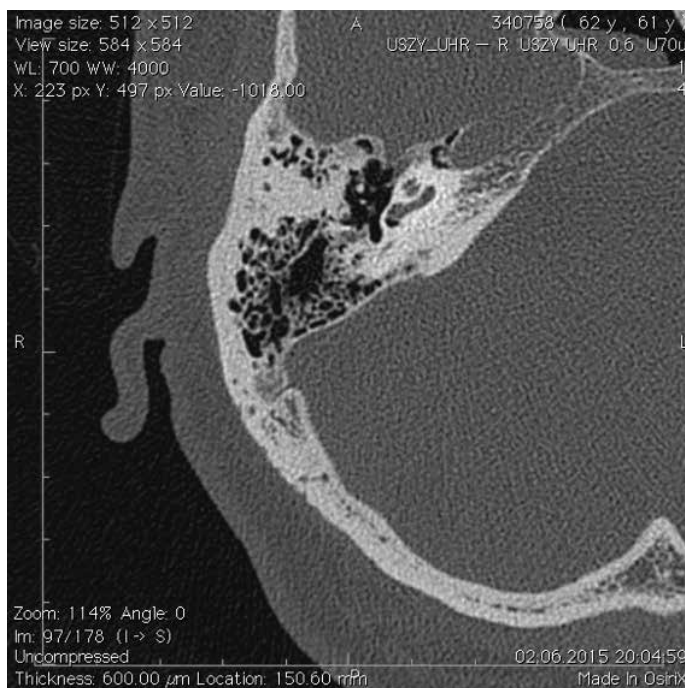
Enlarged axial computed tomography scan of the right temporal bone (the level of the otic capsule and bone window). Air can be seen in the basal turn of the cochlea indicating a pneumolabyrinth (black arrowhead).
